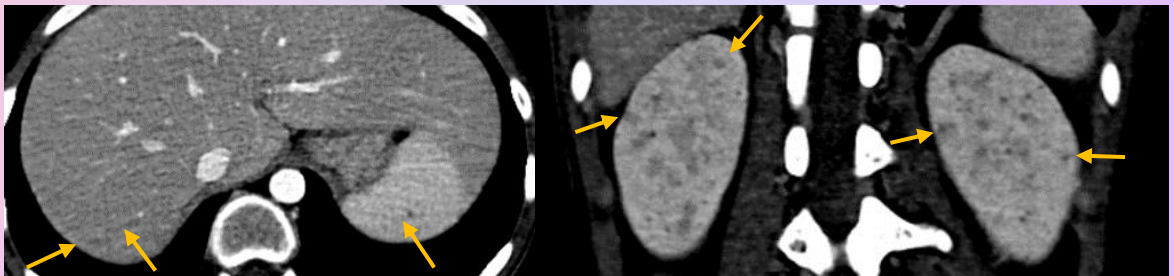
Axial post-contrast CT abdomen showed hypoenhancing nodules at liver and spleen (arrows).
